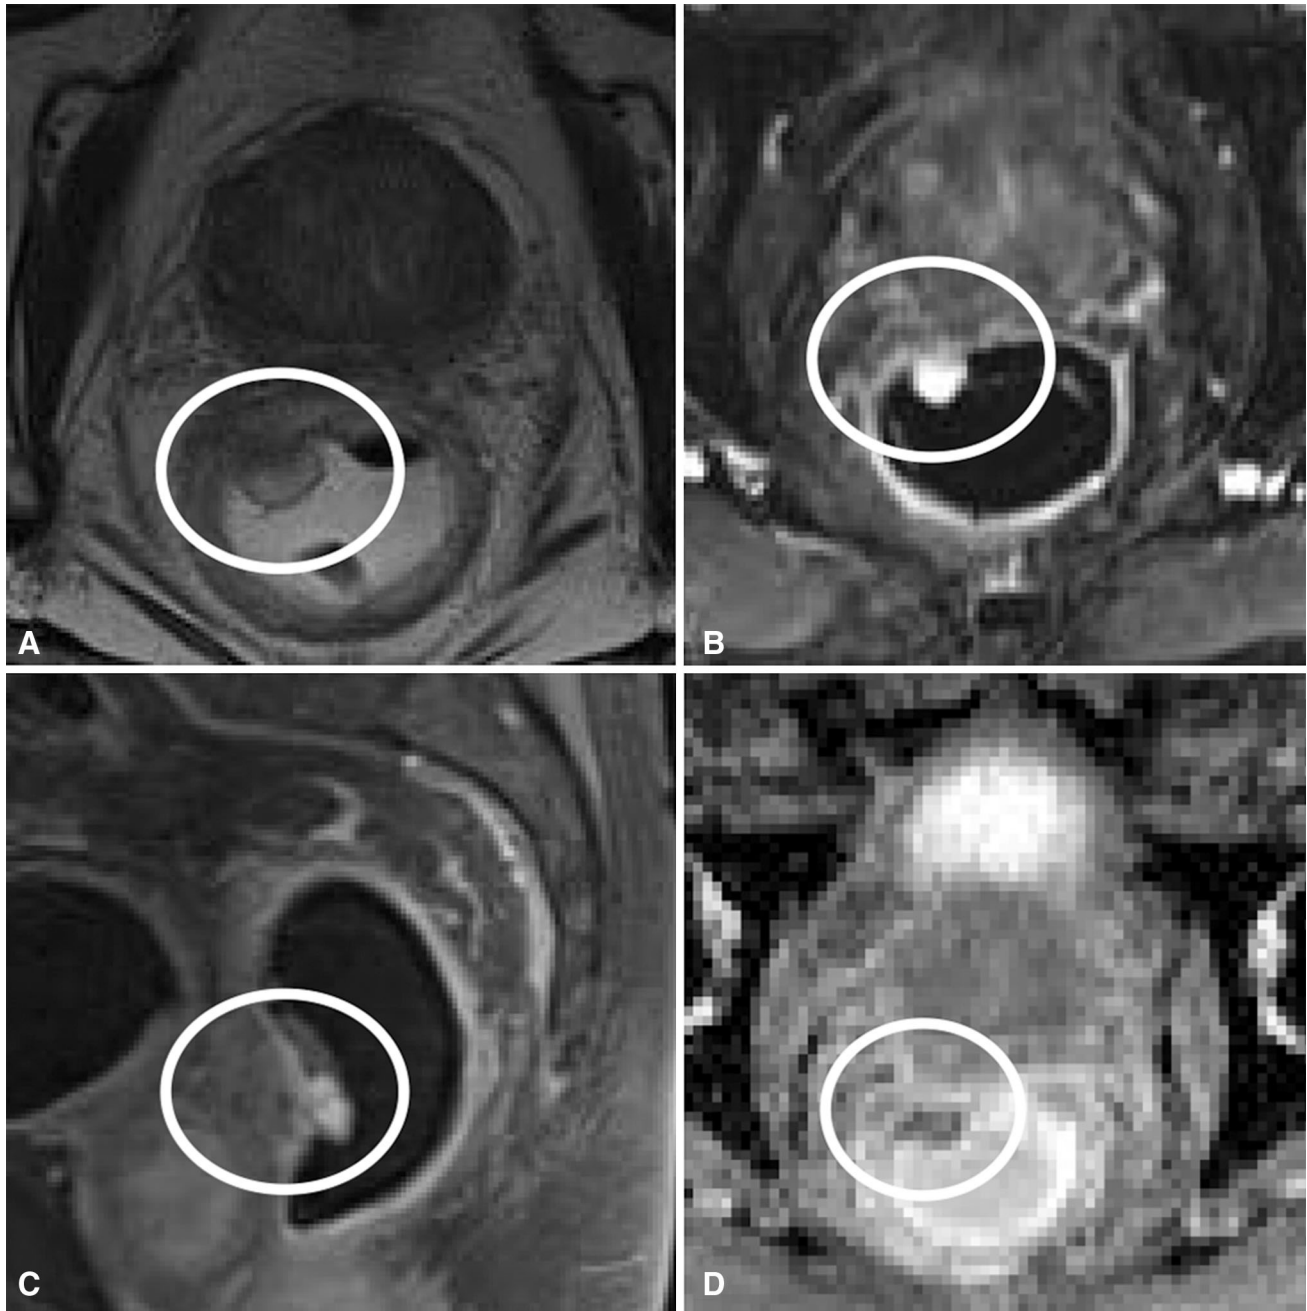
Surgically proven rectal myofibroblastic sarcoma. A Axial T2-weighted MRI with rectal gel shows an intermediate T2 signal polypoid lesion (circled) arising from the right
